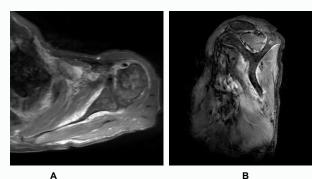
Contrast-enhanced MR imaging obtained at 6 months after surgical drainage. The previously observed abscess was in good condition without recurrence.
